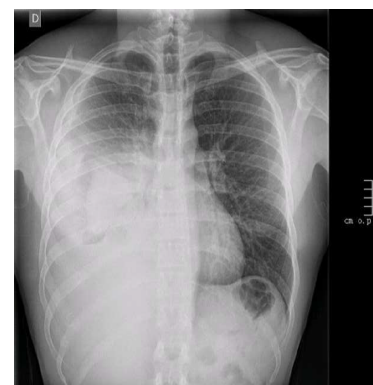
Chest X-ray showing right lower lobe pneumonia with severe empyema.
